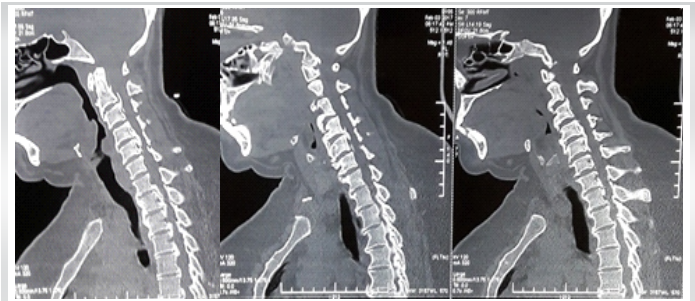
Pre op CT demonstrating Multilevel cervical OPLL
